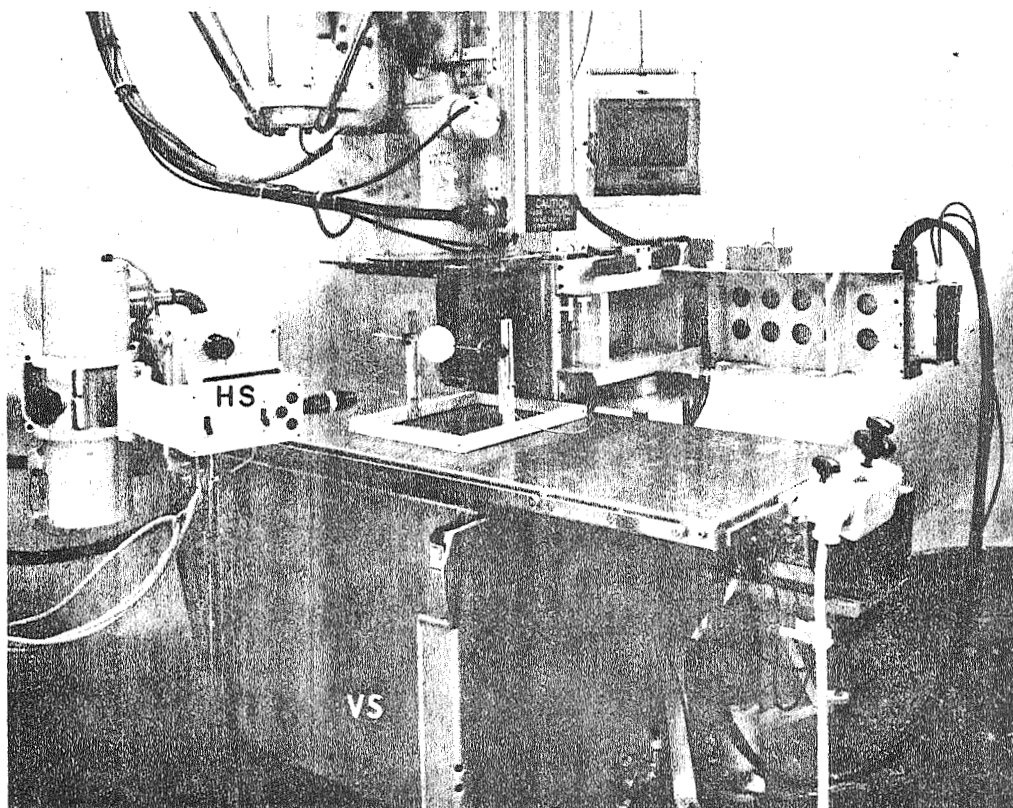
The biplane x-ray image intensifier system as set up for calibration with a radio-opaque ball of known dimensions. The ball is centered at the intersection of the axes of the biplane videoroentgenograph assemblies for the horizontal (source at HS, intensifier at HI) and vertical (source at VS in support of table, intensifier at VI) systems. Since the dimensions of the sphere are accurately known, the image amplifications (and distortions) of the system can be calculated.
